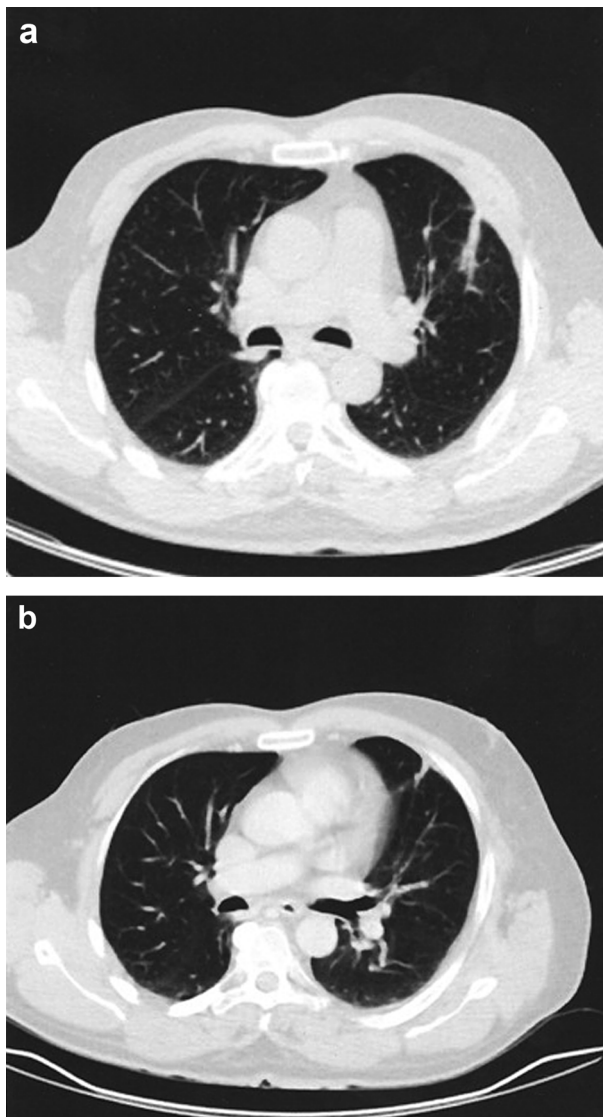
(A, B) Lung CT scan images showing disappearance of the initial lesion, after treatment with heparin in therapeutic dose.
